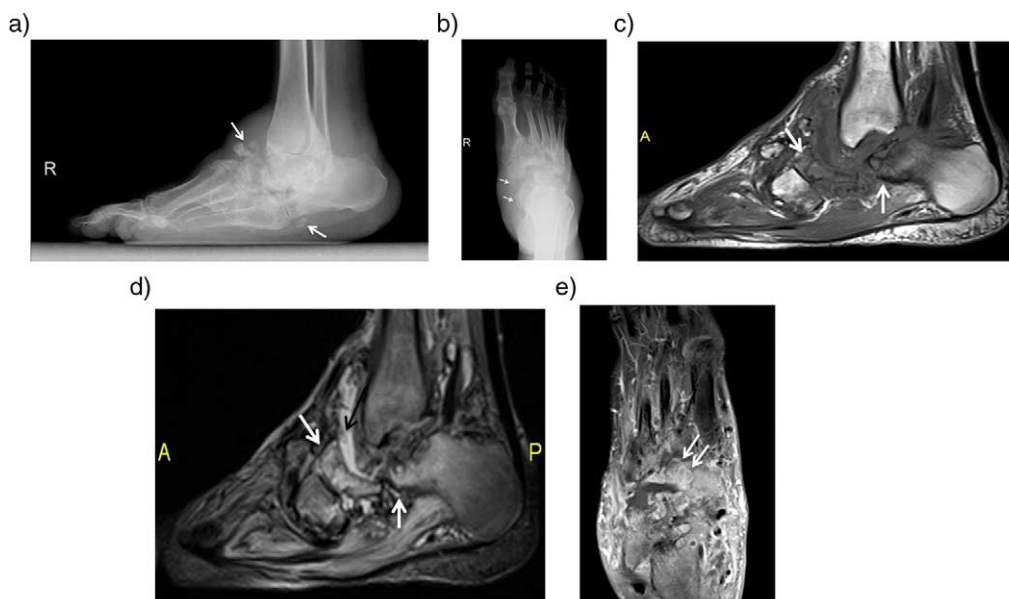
Anteroposterior (a) and lateral (b) plain radiographs of the foot in a 57-year-old diabetic patient with longstanding neuropathic arthropathy show disorganization and fragments (white arrows) along Lisfranc and Chopart joints. Sagittal T1-weighted (c) and T2-weighted fat-saturated (d) images demonstrate periarticular bone marrow edema (white arrows), periarticular soft tissue collections (black arrow) in Chopart joint. Long-axis post-contrast T1-weighted image (e) reveals periarticular rim enhancing cyst formations (white arrows).
